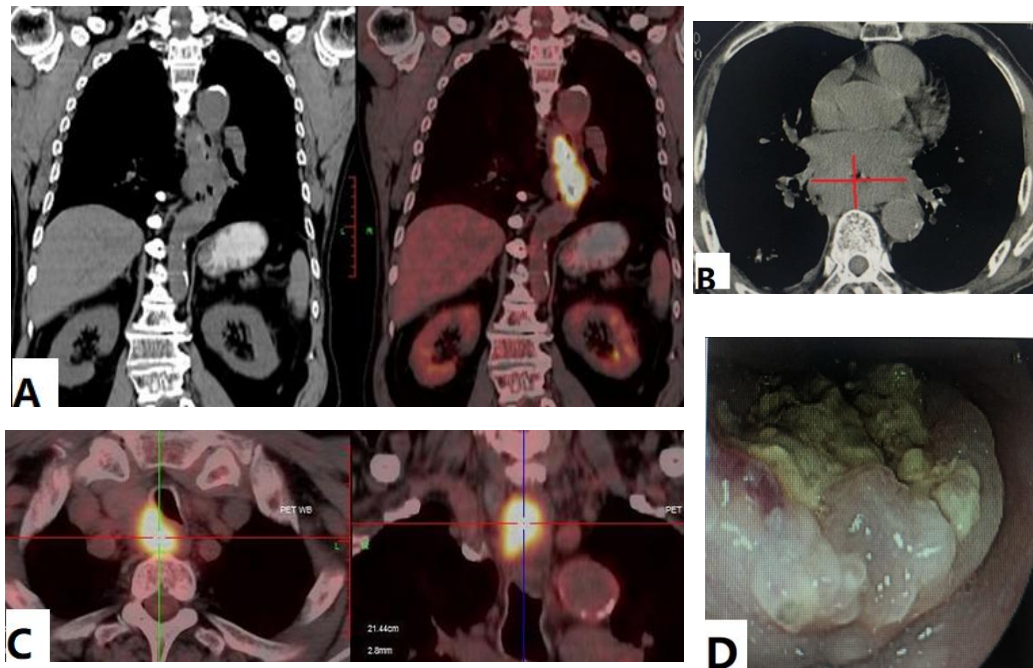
PET-CT, computed tomography and endoscopy demonstrated a tumor sited in the middle and lower esophagus and multiple lymph nodes metastasis. A: PET-CT showed esophageal carcinoma; B: Computed tomography showed esophageal carcinoma; C: Multiple lymph nodes metastasis; D: Endoscopy outcome
